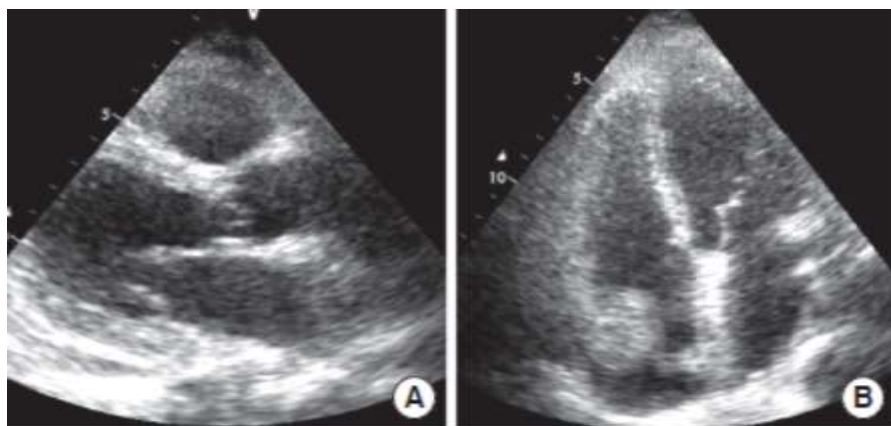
Echocardiography of the patient with parasternal long axis view (A) and para apical four chamber view. Demonstrates presence of pericardial effusion without hemodynamic compromise.
